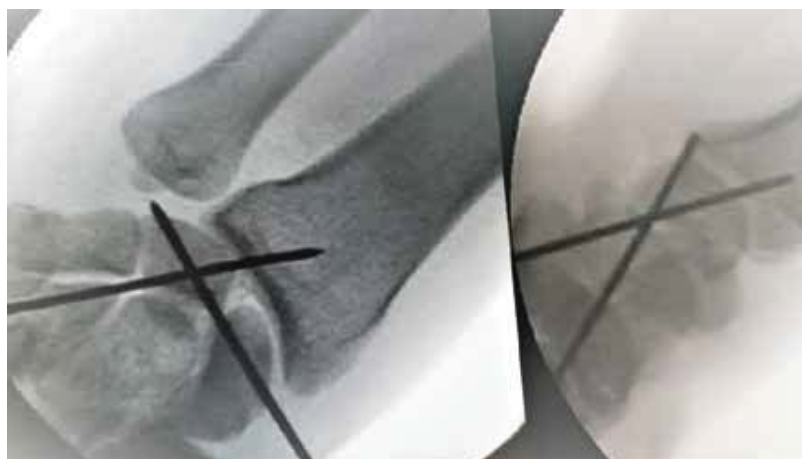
B: Intraoperative Radiographs Displaying K-Wire Fixation of the Lunate Following Closed Reduction in Case 2 (Lateral and Oblique Views)
